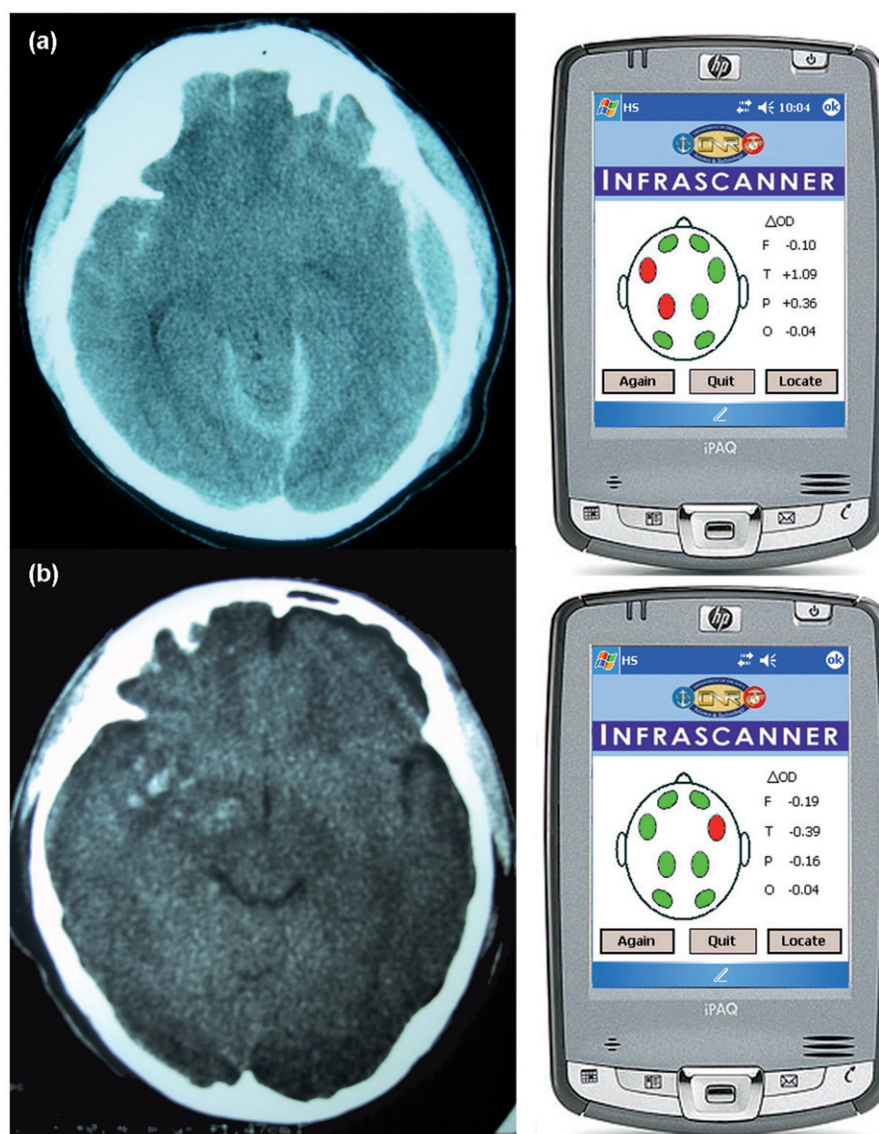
Examples of pathological CT scans and Infrascanner detections. Images on the left show CT scan results. Images on the right show corresponding haematoma detection by the Infrascanner exam. (a) CT showing left temporal and parietal epidural haematoma and its detection by the Infrascanner. (b) CT showing small intraparenchymal contusions and their detection by the Infrascanner.
